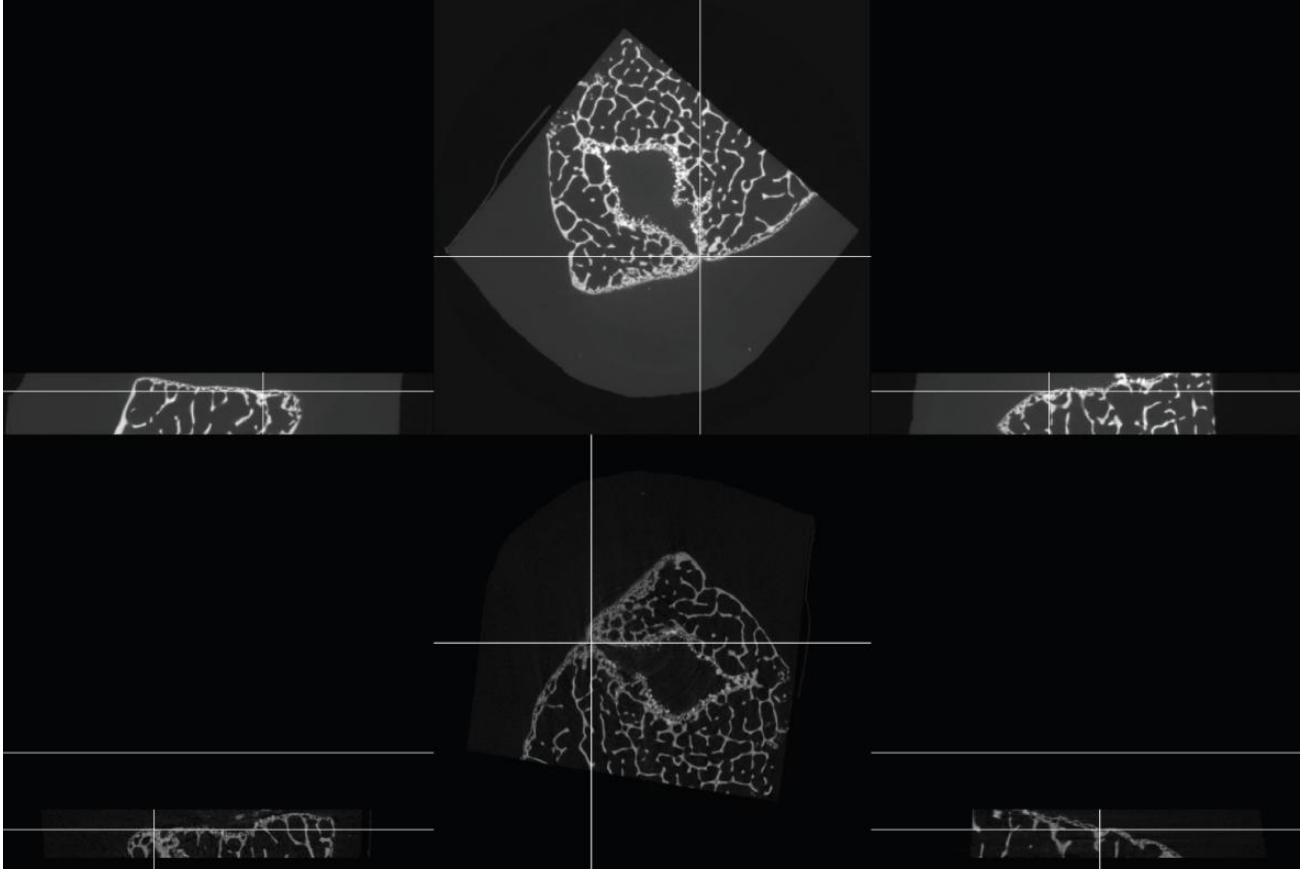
The vertebral body is represented by slices in the three orthogonal directions for pre-registration of the SR μ CT-data (top) with the other μ CT-dataset (below). For each modality, one selects three corresponding landmarks, which define the transform for pre-registration.
